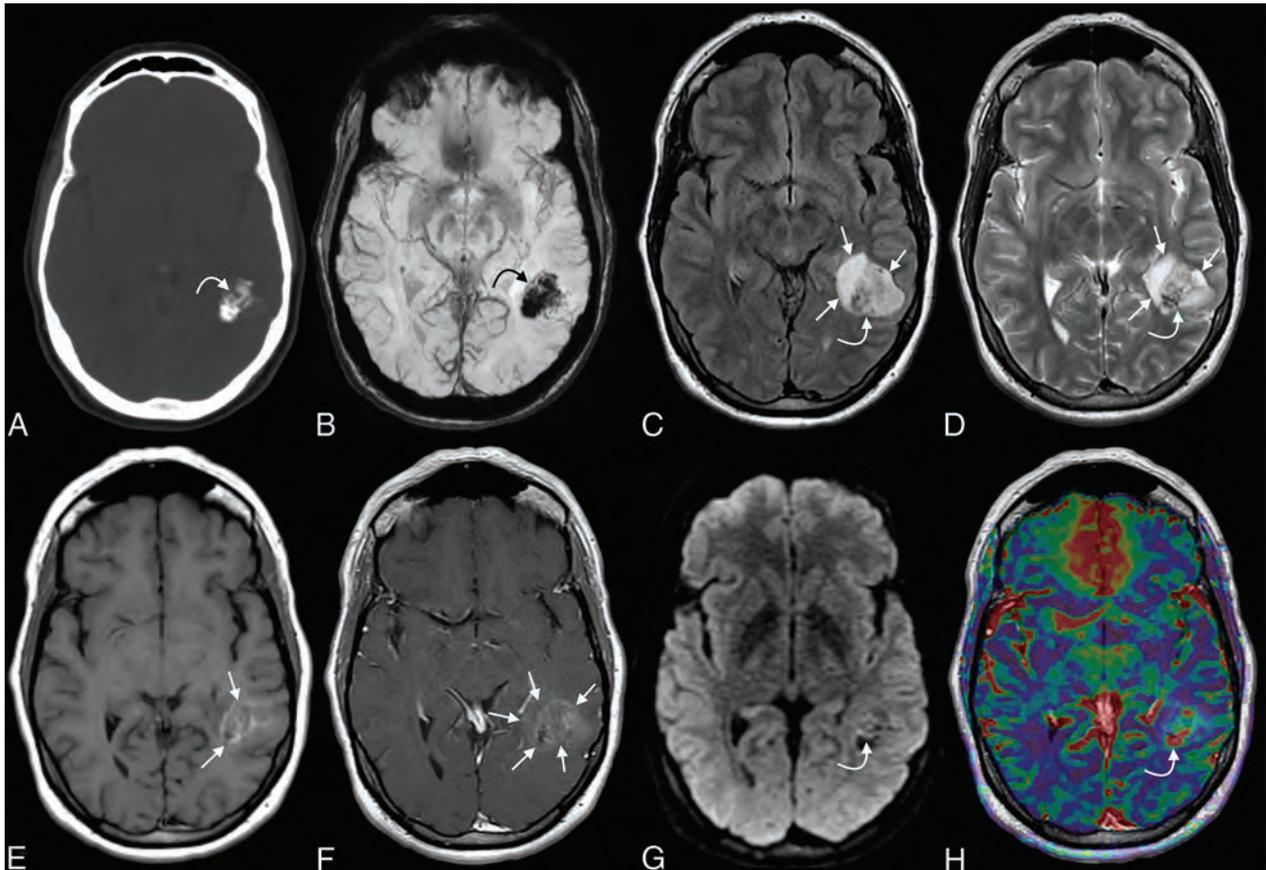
Initial CT and 1.5T MR imaging. Axial CT (A) image shows a sharply delineated mass within the left temporal lobe with dense intralésional calcifications, with blooming signal on the corresponding SWI (B) (*curved arrows* in A and B). Heterogeneous signal was noted within the mass on both FLAIR (C) and T2WI (D) (*curved arrows* on C and D). Some peripheral areas appeared cystic (*straight arrows*, C and D). No substantial surrounding vasogenic edema was observed. A mild associated mass effect was observed, including partial effacement of the left lateral ventricle. Faint T1-hyperintense signal was noted in the central components of the tumor (*straight arrows*, E), while a greater extent of the mass demonstrated mild enhancement (*straight arrows*, F). A few tiny foci of mildly restricted diffusion were observed centrally (*curved arrow*, G), which corresponded with low-intensity signal on ADC images (not shown), though these may have been artifactual because no high-grade features were seen on pathology. Some of the solid-appearing components demonstrated elevated relative CBV (*curved arrow*, H).
